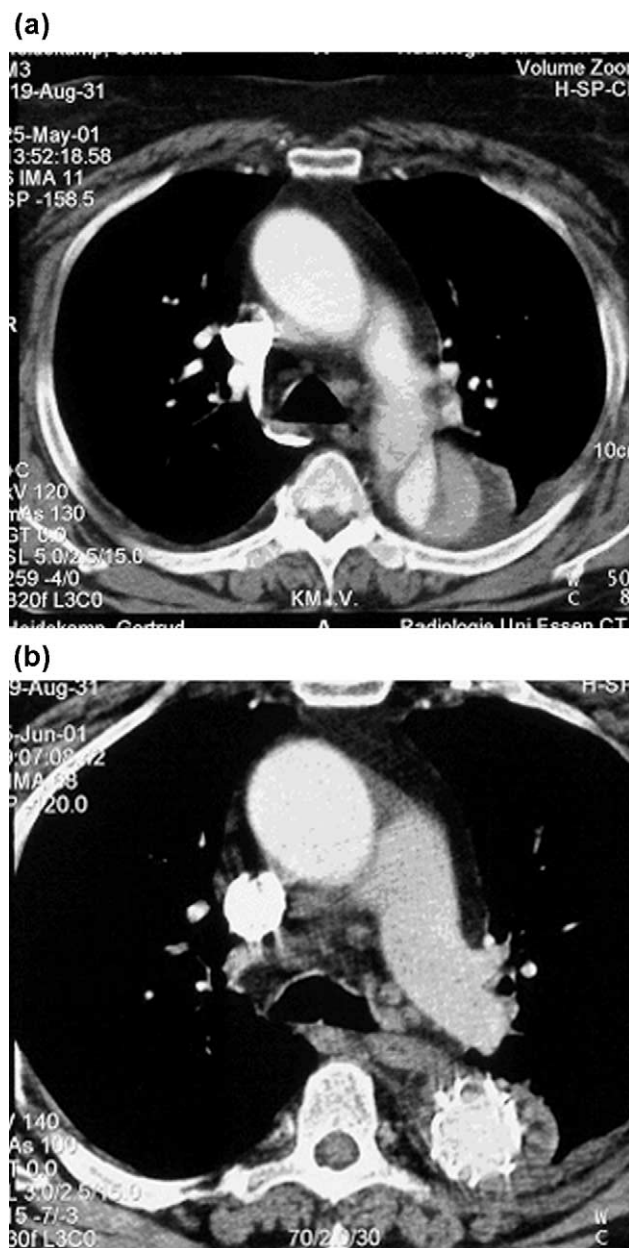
Sixty-nine-year-old female patient with an acute type B dissection beginning directly after the left subclavian artery on CT (a). Control CT shows the restoration of the true lumen and subsequent thrombosis of the false lumen (b).
